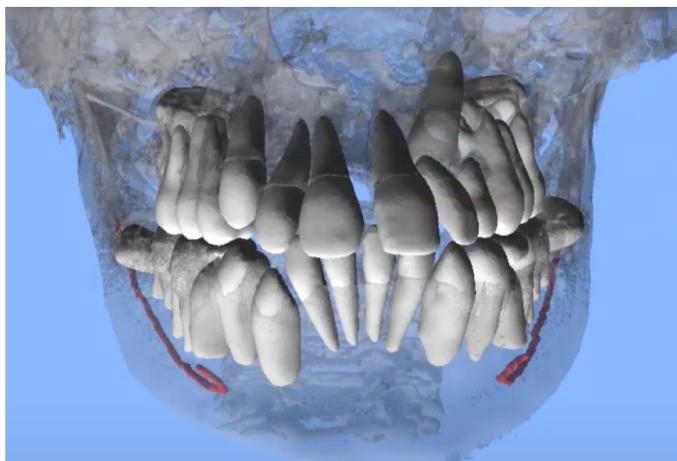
CephX CBCT segmentation. Photo courtesy of Orca-AI.
